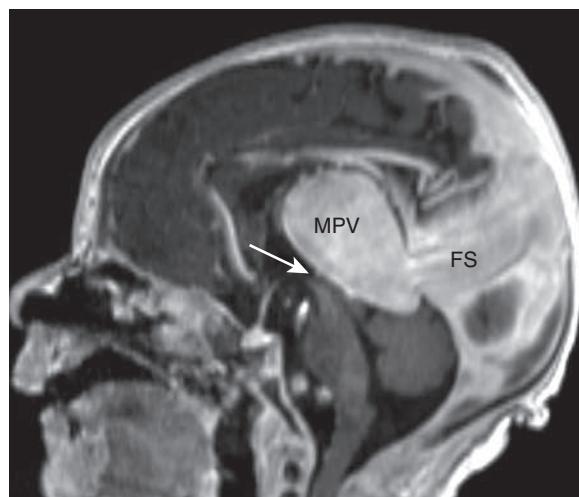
Vein of Galen malformation. A vein of Galen malformation is an arteriovenous fistula between intracranial arteries and the embryologic median prosencephalic vein. As seen in this postcontrast sagittal T1-weighted brain MR image of a newborn with a prenatally diagnosed vein of Galen malformation, this vascular malformation is characterized by marked distension of the median prosencephalic vein (MPV) and distension of downstream dural sinuses, commonly through a persistent embryologic falcine sinus (FS). The ensuing high-velocity arteriovenous shunting can cause venous hypertension, communicating hydrocephalus, and high-output cardiac failure. Although large median prosencephalic veins can compress the cerebral aqueduct (arrow), the primary treatment modality is still endovascular intervention (embolization) rather than CSF diversion.
